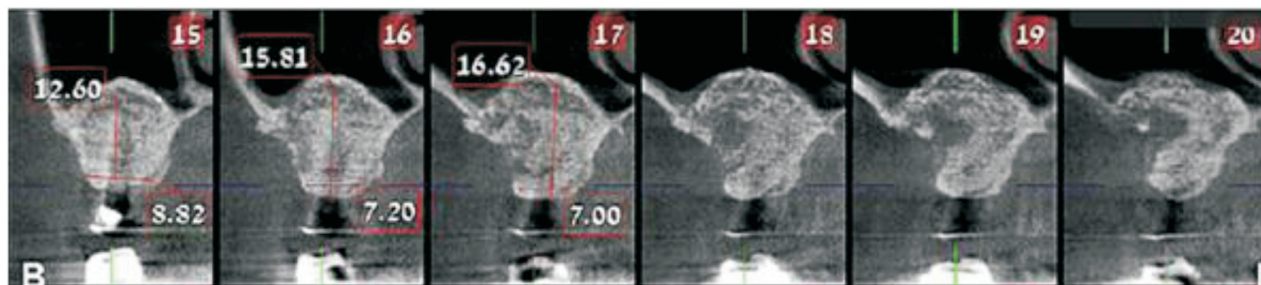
CT scan showed a radiolucent area in the center of the grafted area with a cloud-shaped radiopacity at the most superior border of the sinus cavity.
